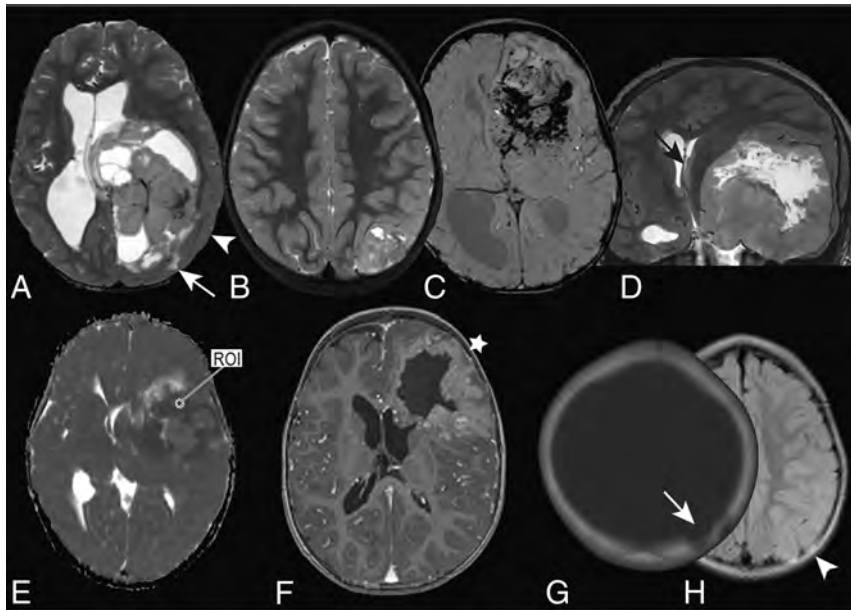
Typical imaging characteristics of CNS NB-FOXR2 in different patients (A, A 2.5-year-old girl; B, G, H, A 3-year-old girl; C, A 4.2-year-old girl; D, A 16-year-old boy; E, A 4-year-old boy; F, A 2.7-year-old boy). Most tumors were characterized by T2WI signal heterogeneity but always contained hyperintense regions compared with cortical GM (A and B). In most, no or limited perilesional edema (arrow in A) was found. When gradient-echo images (T2*, SWI) were available, signal loss was detected in about half of the cases (C). An example of nodular, leptomeningeal metastases at the foramen of Monro is shown in D (black arrow). In general, ADC values were relatively low. An example is given in E: ADC_{mean} in a ROI placed within the solid tumor component is $660 \times 10^{-6} \text{ mm}^2/\text{s}$ (ADC_{minimum} , $550 \times 10^{-6} \text{ mm}^2/\text{s}$; ADC_{maximum} , $760 \times 10^{-6} \text{ mm}^2/\text{s}$). Contrast enhancement on T1WI was mostly mild to-intermediate compared with the choroid plexus and seen in larger parts of the solid component (F). Nonsolid tumor components with thick, irregular borders were often noted representing necrotic regions (F). The main tumor load was often located in the WM with compression (arrowhead in A) or infiltration (star in F) of the overlying cortex, or it appeared to originate from the cortex (B). Skull remodeling was detected in about half of the cases (arrow on CT in G), often associated with bony signal changes (arrowhead, H).
